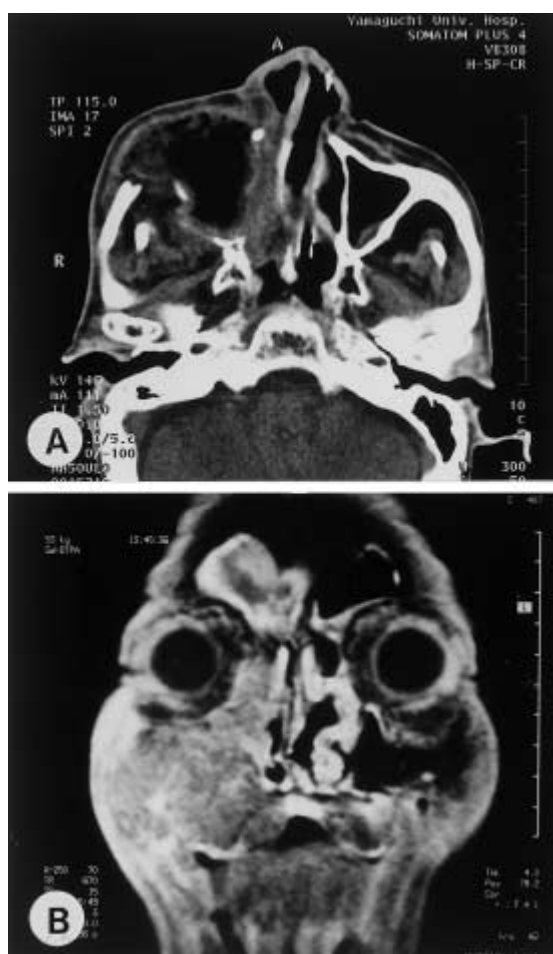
Magnetic resonance image revealed bony destruction and ethmoidal sinuses involvement by tumor.
